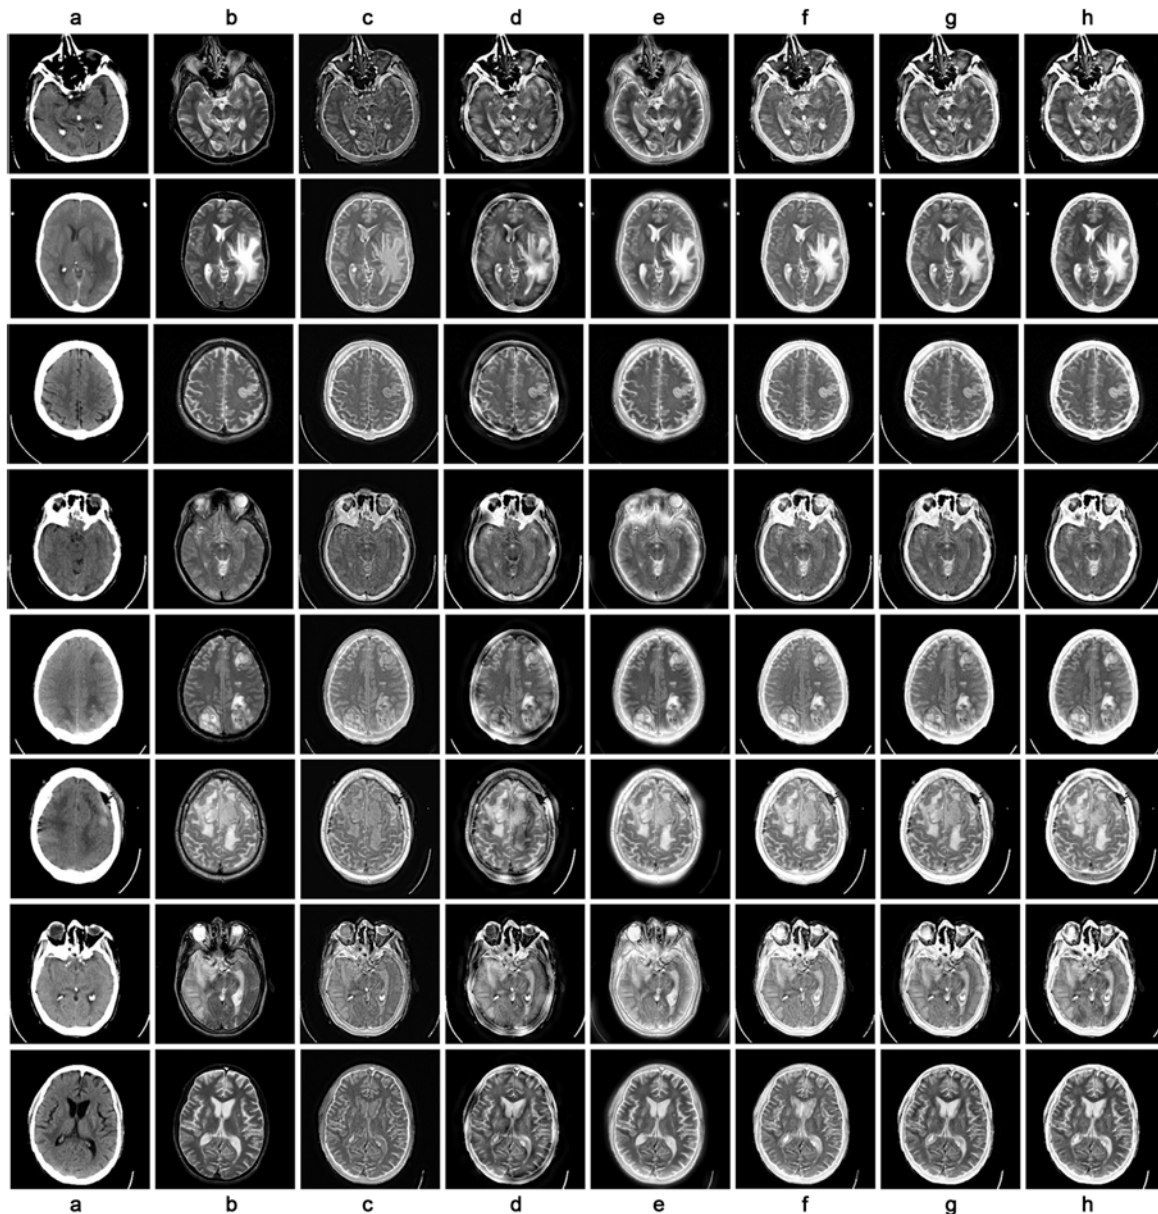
(a) CT images, (b) MRI images, fused images by (c) M1 [22], (d) M2 [19], (e) M3 [27], (f) M4 [23], (g) M5 [20], and (h) M6.
